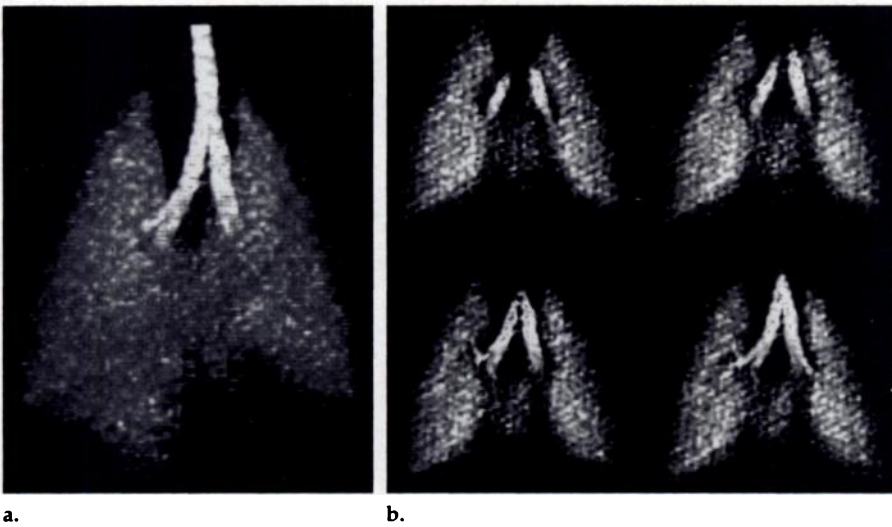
He-3 MR images depict (a) volume-rendered image from a three-dimensional data set and (b) individual sections from the same data set.
